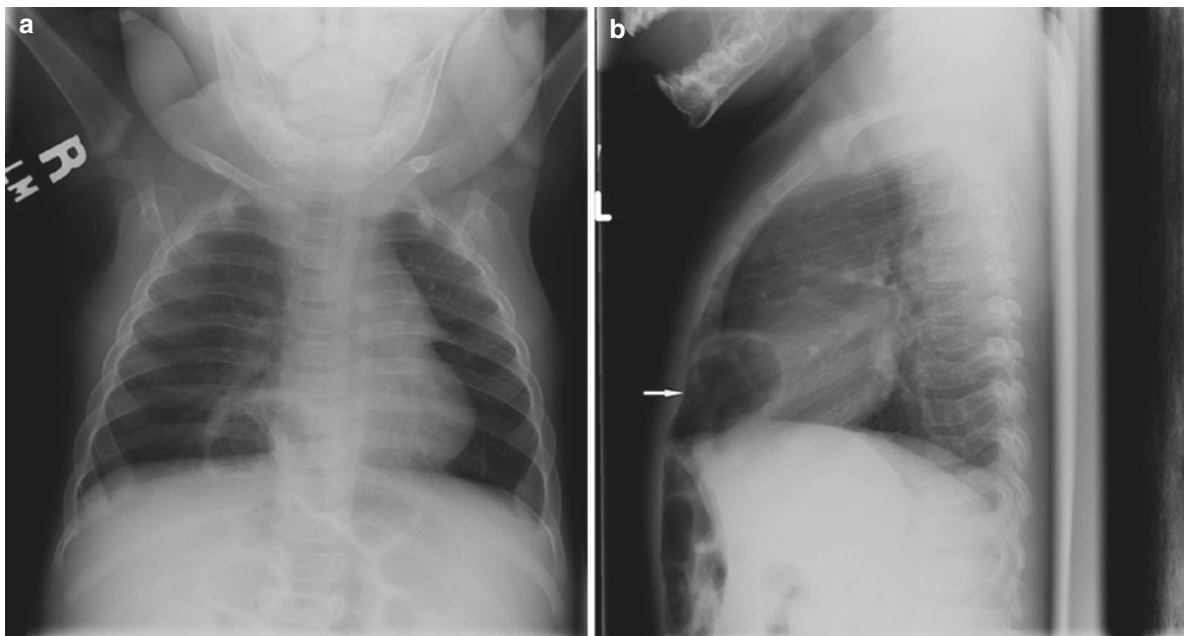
(a, b) Congenital diaphragmatic hernia. Foramen of Morgagni defect. (a) This AP chest radiograph depicts a neonate with congenital diaphragmatic hernia with a loop of bowel that herniated through a defect in the anteromedial (retrosternal) area of the diaphragm (foramen
